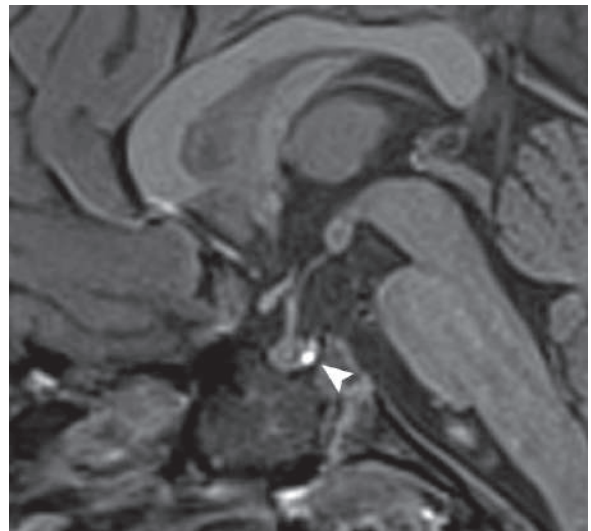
Sagittal nonenhanced T1W MRI of the sella shows the physiological bright signal of the posterior hypophysis (arrowhead)
